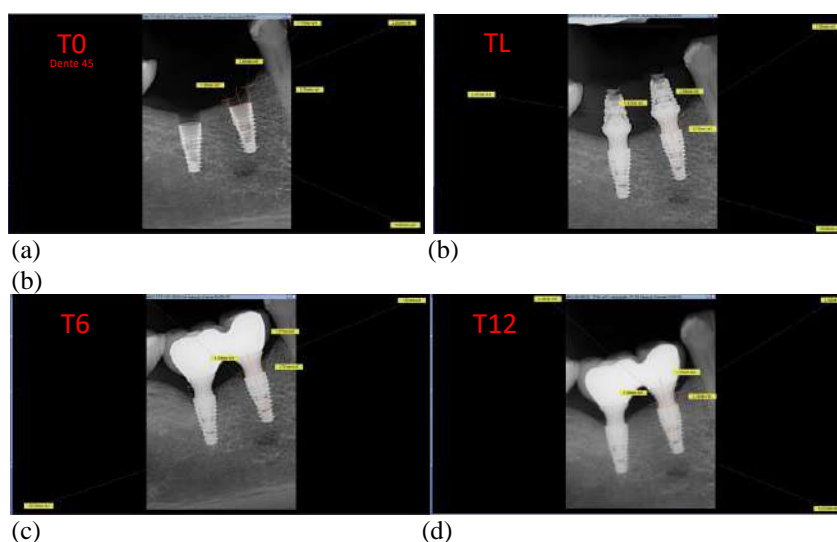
Radiographic measurements T0 (a), immediate loading (b), definite crown placement after 3 months (c), 6 months after surgery T6 (d), one year after surgery T12 (e).
